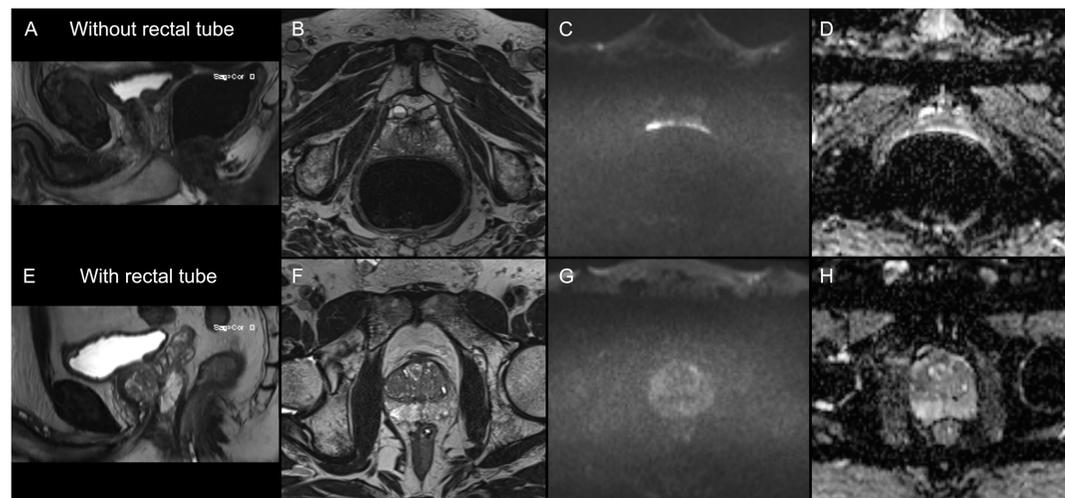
Multiparametric MRI of the prostate without rectal tube versus with rectal tube. 70-year-old man who underwent prostate mpMRI without rectal tube demonstrates a large volume of rectal gas with a score of 5 (large rectal gas present) from both readers on T2WI sagittal (A) and axial (B) images, 5 (severe) DWI distortion (C) and 5 (poor) ADC map quality (D). 60-year-old man who underwent prostate mpMRI with the placement of rectal tube received a score of 1 (none/excellent) from both readers for all image parameters including presence of rectal gas on T2WI sagittal (E) and axial (F) images, DWI distortion (G) and ADC map quality (H).
